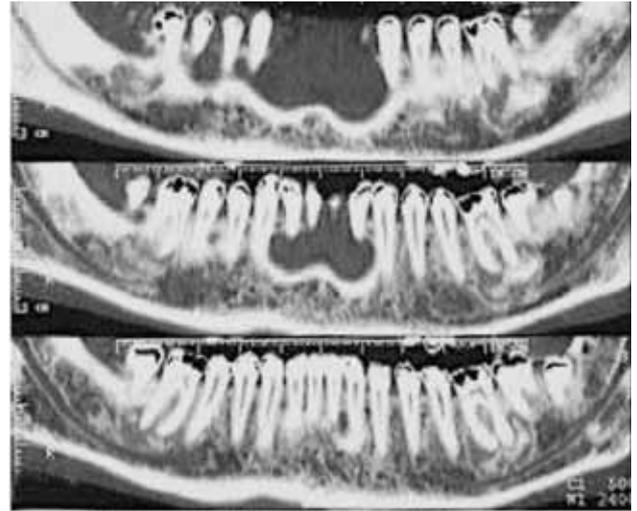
CBCT of the mandible that revealed the absence of the erosion of both the lingual and buccal cortices; both lesions involved the mandibular canal.
